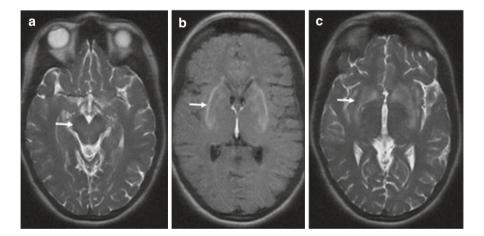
MRI of the brain at the time of diagnosis. The patient was 20-year-old woman who was diagnosed 14 months after exhibiting first symptoms. Faint T2 hyperintensity was observed in upper brainstem (panel a). Increased T2 signal in basal ganglia (panels b and c) is suggestive of WD
